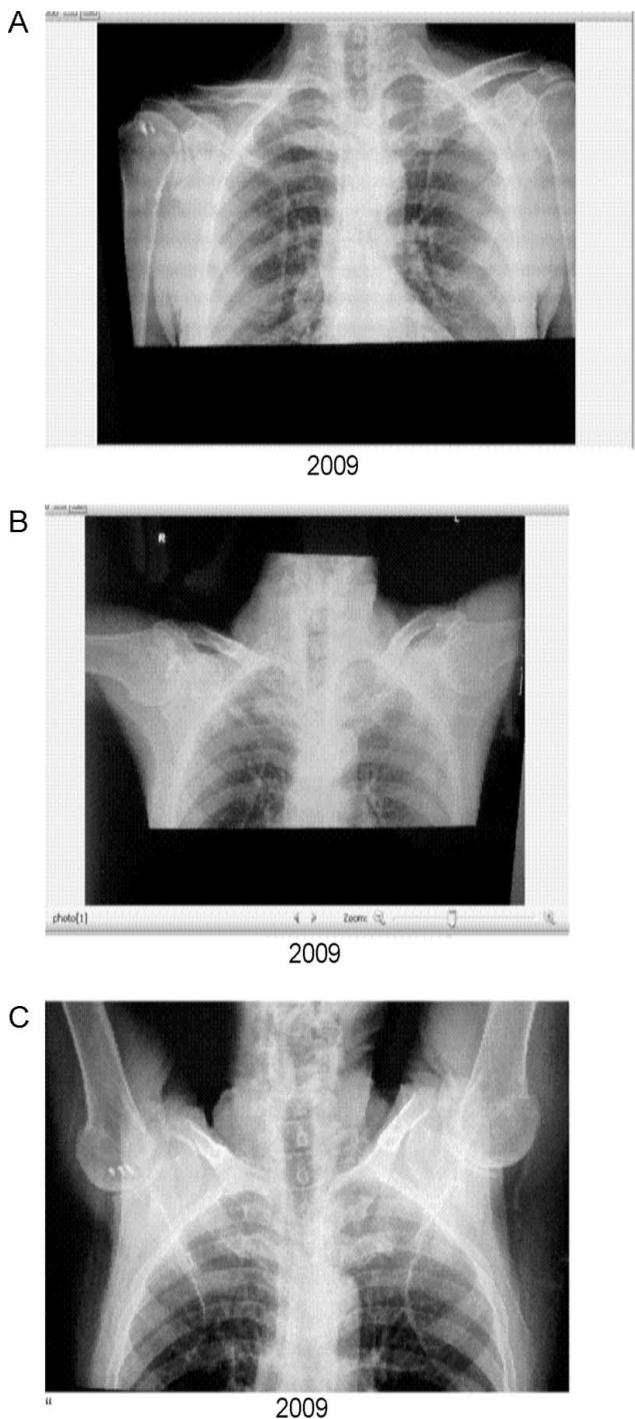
X-ray study 6 years following triangular forearm support in a 68-year old with massive left rotator cuff syndrome and earlier surgical revision of dominant right supraspinatus tear. High riding left humeral head and glenoacromial pseudoarthrosis (A) nevertheless allows painless full range of abduction through downward pull on humeral head with abduction. B, C, The deltoid raises the arm on the left to 90°, but the horizontal vector of the deltoid will not raise the arm on the right beyond 90° without help.
